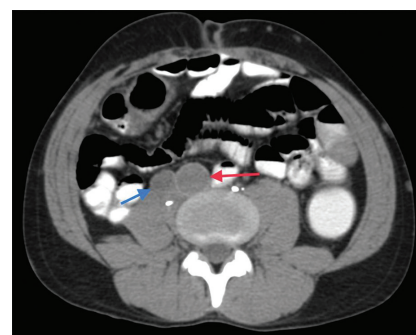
Postoperative CT abdomen shows no residual/recurrent disease. Grafted aorta and IVC are shown with red and blue arrows, respectively.
